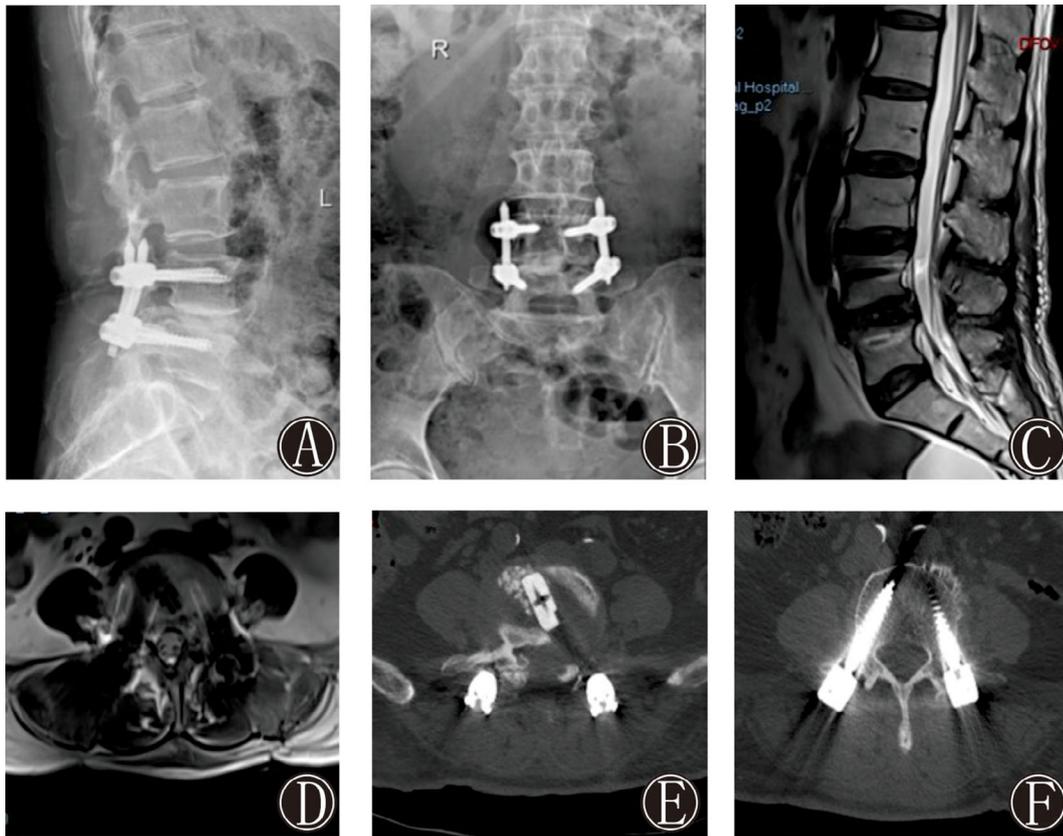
The postoperative right lateral (A) and anteroposterior (B) X-ray images showed the final construct with the cage and percutaneous pedicle screws. No signs of spinal cord compression were found in the sagittal (C) or axial MRI scans (D) taken at 3 days postoperatively. The CT axial scans of the lumbar spine (E and F) taken on postoperative day 3 indicated that full decompression was performed. The pedicle screws and fusion device were well positioned.
